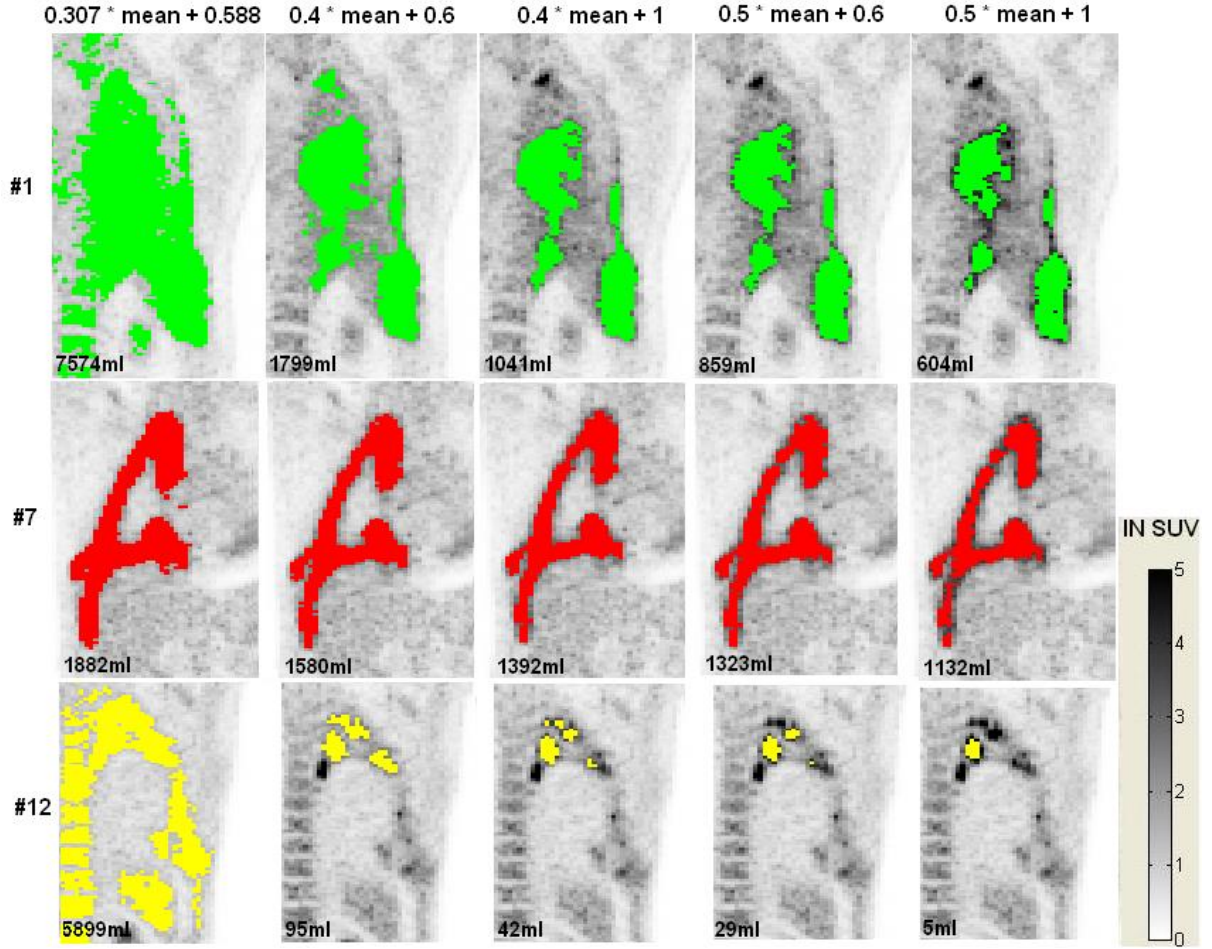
Segmentation using SUV_{mean} Threshold Calculation Method
